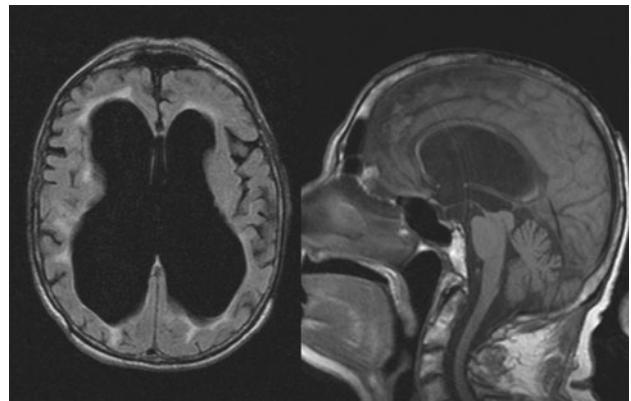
Axial T2 (Flair) weighted MRI image showing considerable triventricular hydrocephalus in benign aqueductal stenosis. Sagittal T1 weighted MRI image showing remarkable dilation of Monroe hole and secondary corpus callosum atrophy
